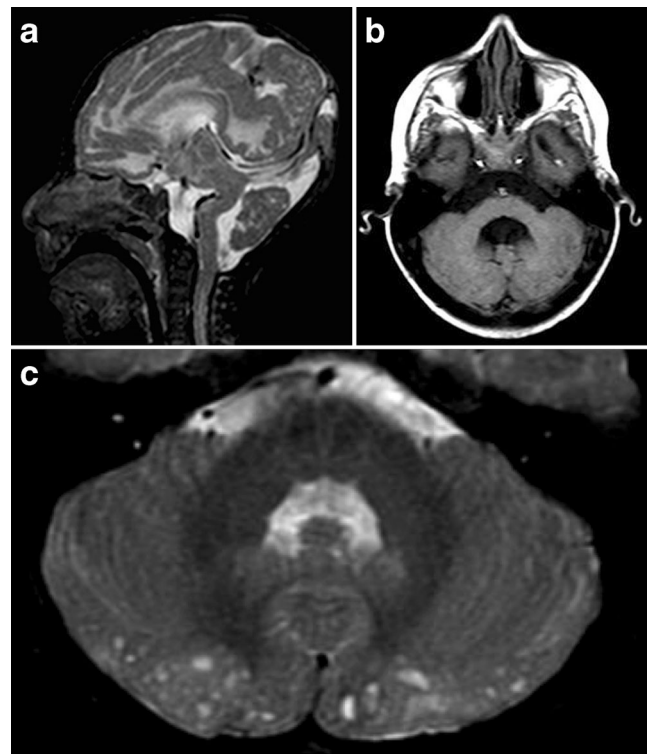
MR images demonstrate patterns of infratentorial abnormalities. a A 6-month-old boy with MCD (Walker–Warburg Syndrome). Sagittal T2-weighted image demonstrates occipital encephalocele (after partial surgical correction) and hypoplastic brainstem, particularly in the pons. There was also posterior kinking, resulting in a broad inverted S-shaped brainstem. b A 4-year-old girl with CMD. Sagittal and axial pre-gadolinium-enhanced T1-weighted images reveal flattening of the ventral portion of the pons, enlargement of the midbrain tectum, subtle mid-pons kink and vermian hypoplasia. c A 6-year-old boy with MCD. Axial T2-weighted image demonstrates dysmorphic hemispheric cerebellar cortex with small cyst-like structures
